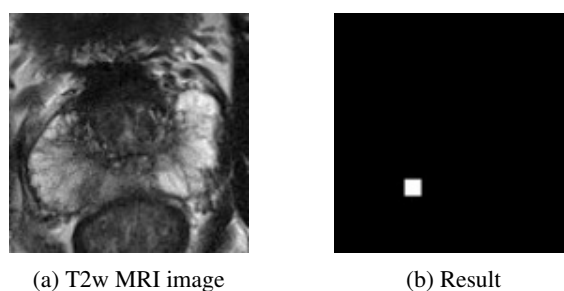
mp-MRI used images.
